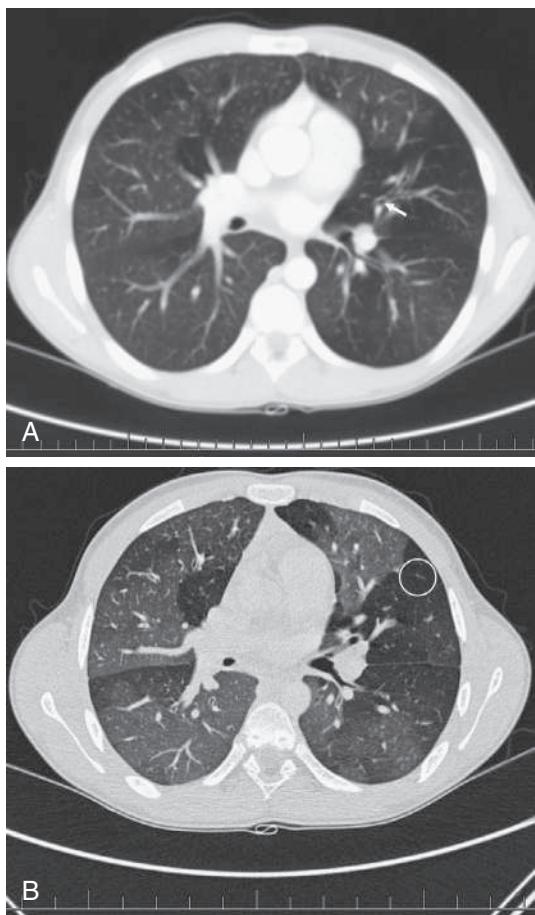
Chest CT from an 11-yr-old patient with bronchiolitis obliterans after Stevens-Johnson syndrome. A, Volumetric scan at full inspiration shows central bronchiectasis (arrow) and mosaic attenuation. B, High-resolution image taken in exhalation better highlights the mosaic attenuation and vascular attenuation (circle).
